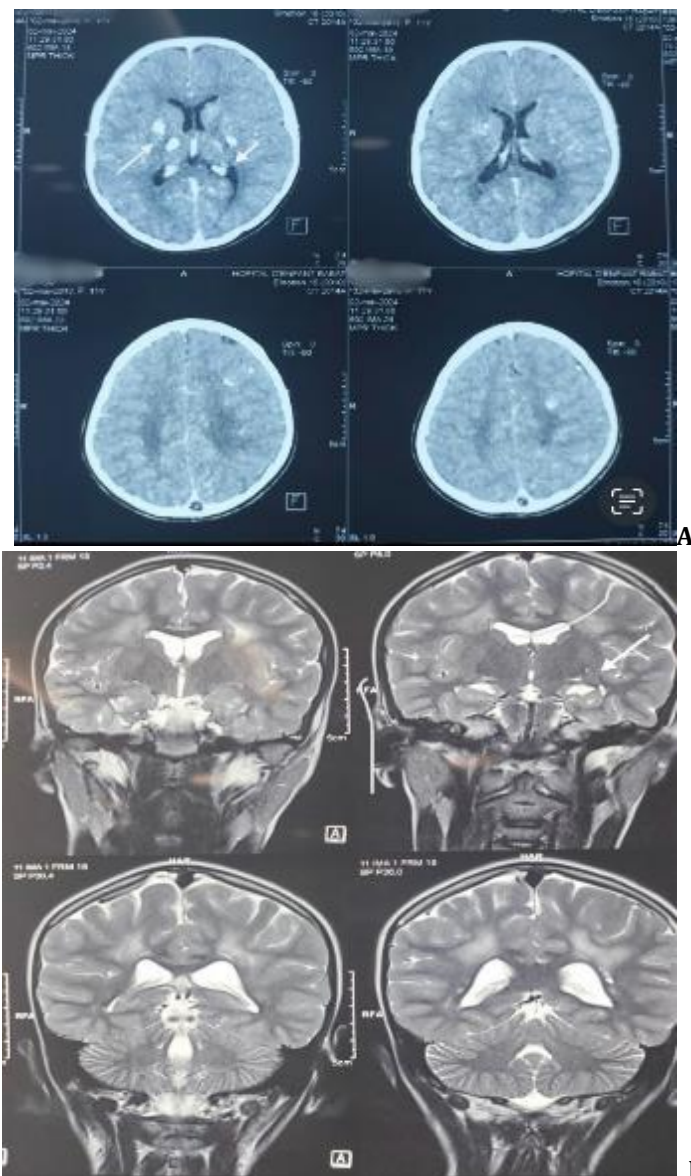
A Injection-free CT scan showing bilateral asymmetric calcifications of the basal ganglia.
